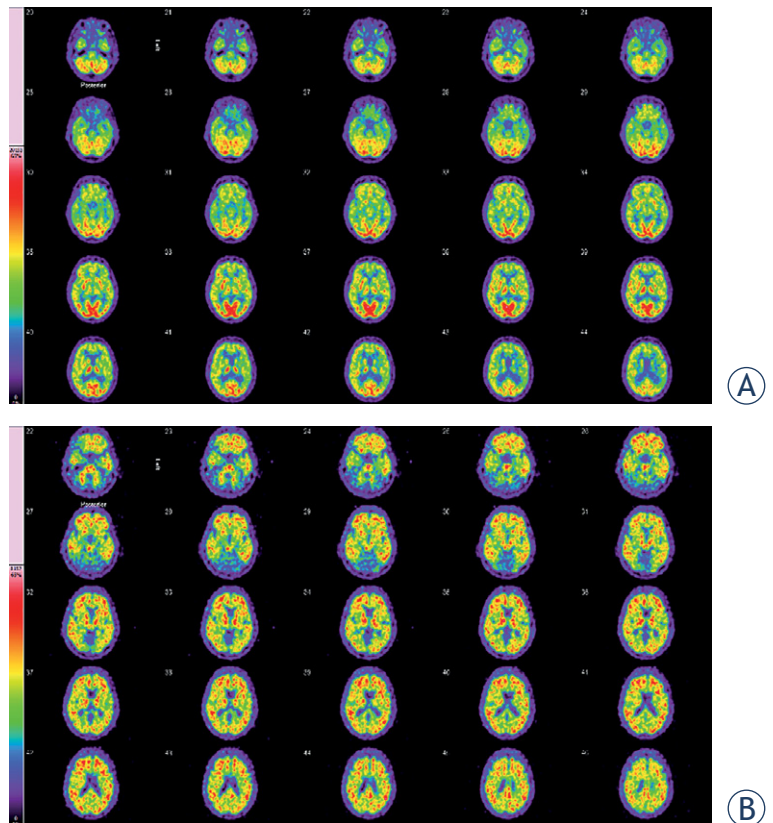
FDG and amyloid brain PET/CT of a 70-year-old woman. (A) 2-[18F] fluoro-2-deoxy-d-glucose (FDG) brain PET/CT of a 70-year-old woman, who presented with a history of cognitive decline (mini mental state examination [MMSE] = 15/30). The glucose metabolism in the cerebral cortex is inhomogenous and moderately attenuated. In the cerebellum, normal glucose metabolism was demonstrated. This FDG brain PET study does not show the typical picture of abnormal glucose metabolism that occurs in Alzheimer's disease (AD), but temporomesial and temporolateral some decreased tracer uptake can be observed. Additionally the images are compatible with pronounced microvascular changes. (B) Amyloid PET images demonstrate pathologically increased tracer accumulation in the entire brain, more pronounced in the frontal and temporal cortical areas. This is compatible with the diagnosis of AD.
